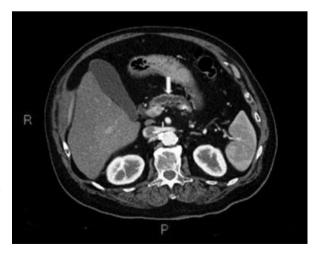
Axial CT scan of a main-duct intraductal papillary neoplasm demonstrating a *dilated main pancreatic duct* (white arrow)
